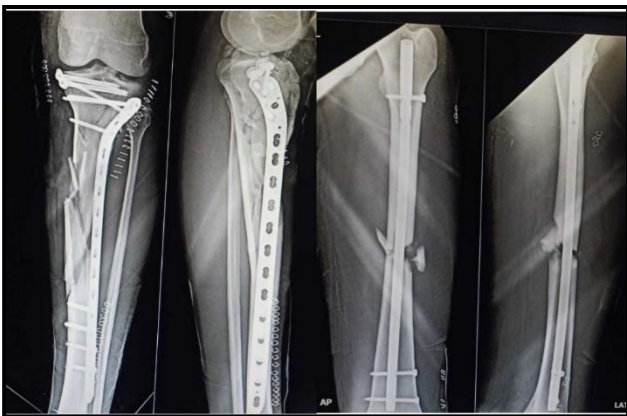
Fraser classification type IIA X-ray of a case after operation.
